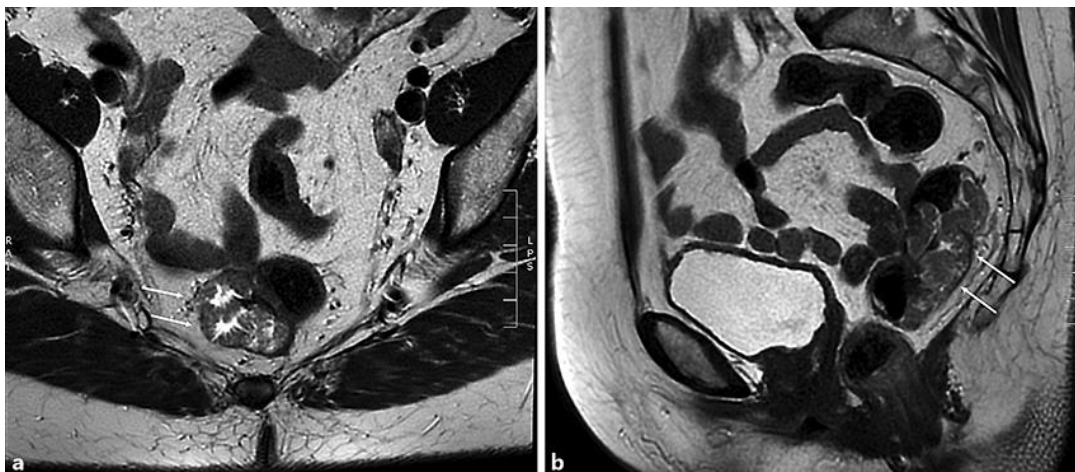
a MRI of the 7 cm large rectal tumor with restriction of diffusion and focus of the probable invasive growth with penetration of the whole thickness of the bowel wall and incipient infiltration of the mesorectal fat. b Mesorectal fascia is intact and the lymph nodes are unsuspecting. There are no signs of vascular invasion.
